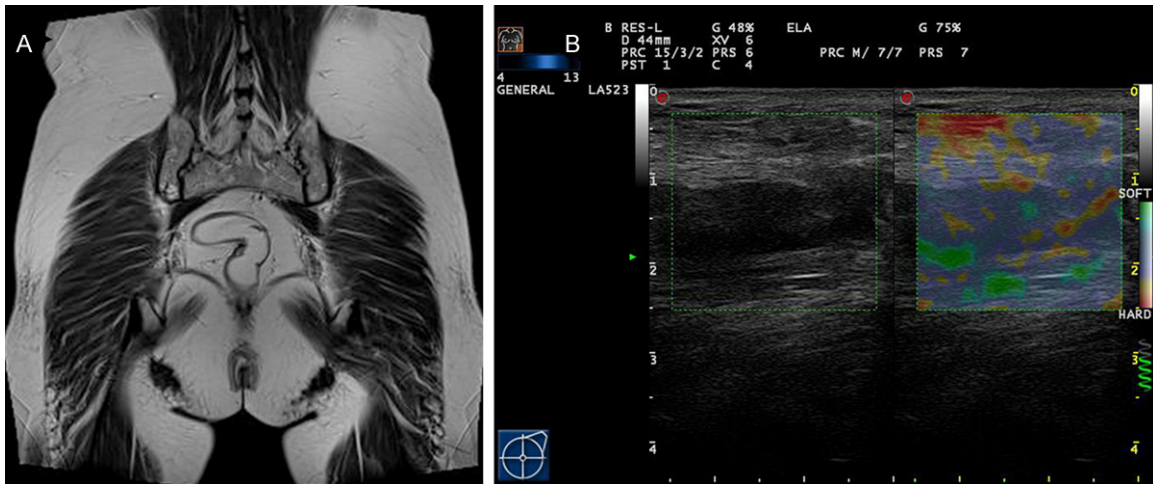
Case 2. A patient of levator ani with no defect detected by MRI (A). ES showed red areas comprising between 10% and 50%, scored as ES2 (B).
